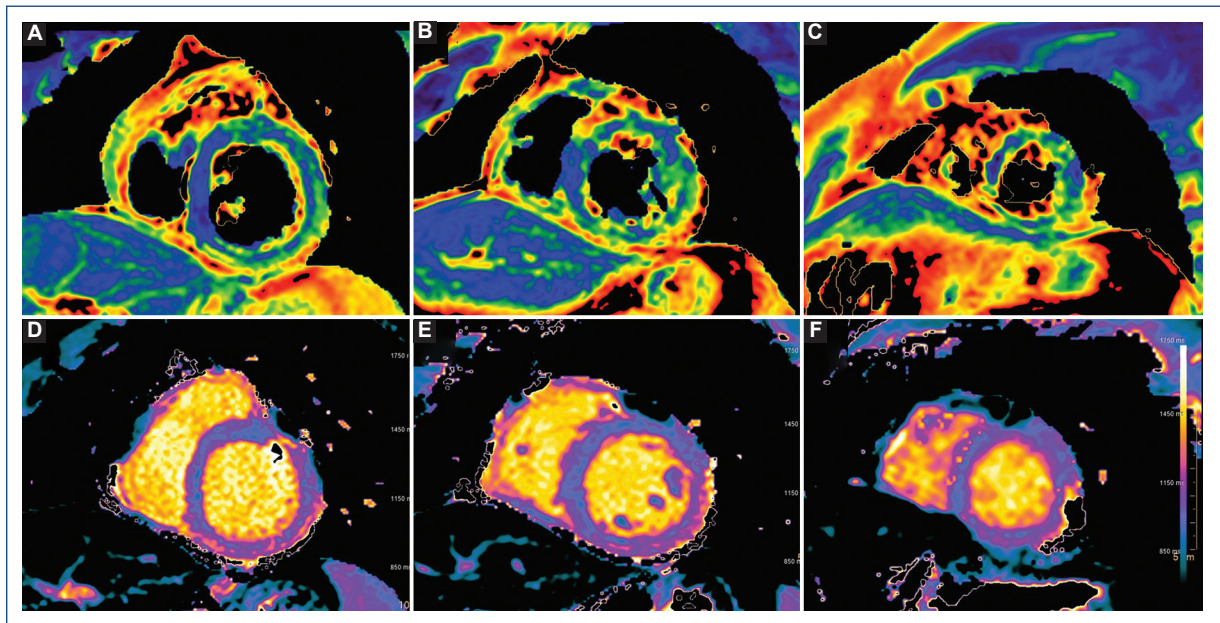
Advanced tissue characterization with cardiac magnetic resonance imaging: T2 mapping sequences. A: basal short axis, note the increased values in inferior and inferolateral segments. B: mid short axis. C: apical short axis. T1 mapping sequences. D: basal short axis, note the increased value in the inferior segment. E: mid short axis. F: apical short axis.
